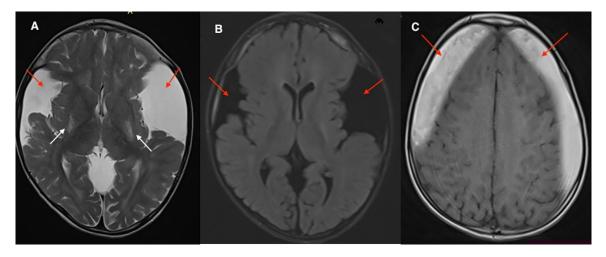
(A) Axial T2 MRI and (B) Axial FLAIR MRI shows widening of the bilateral sylvian cisterns (red arrows) and T2 high signal intensity within the bilateral lentiform nucleus (white arrows in A), (C) Axial T1 MRI shows symmetrical high signal intensity subdural collection suggesting sub-acute hematoma (red arrows).
